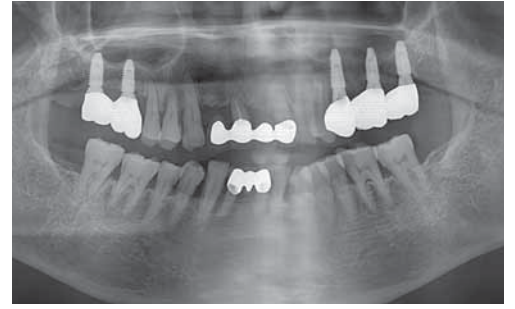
Periapical x-ray of the final prosthesis.
